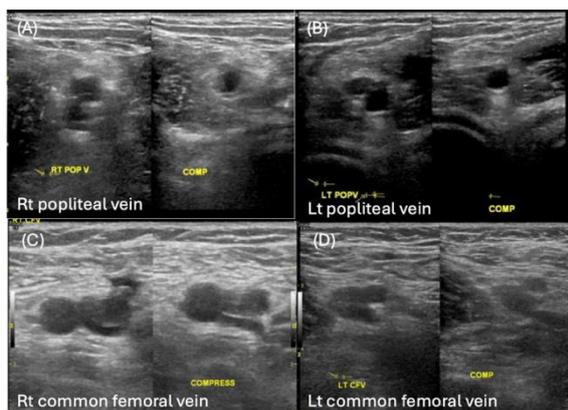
A venous doppler ultrasound of both lower extremities demonstrates enlarged and non-compressible veins of right popliteal vein, left popliteal vein, right common femoral vein and left common femoral vein respectively.
